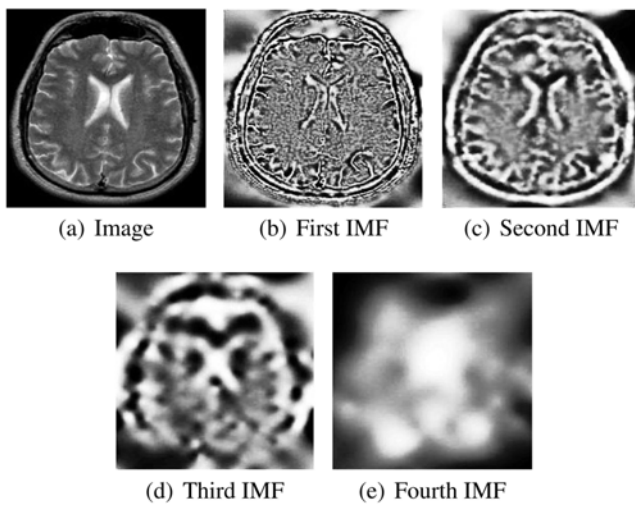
Sample normal brain MR image and corresponding IMFs.
